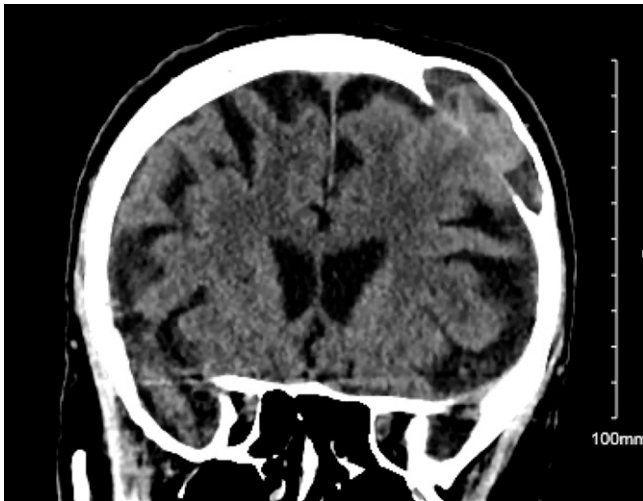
CT without contrast showing cranial deficit and lesion.
